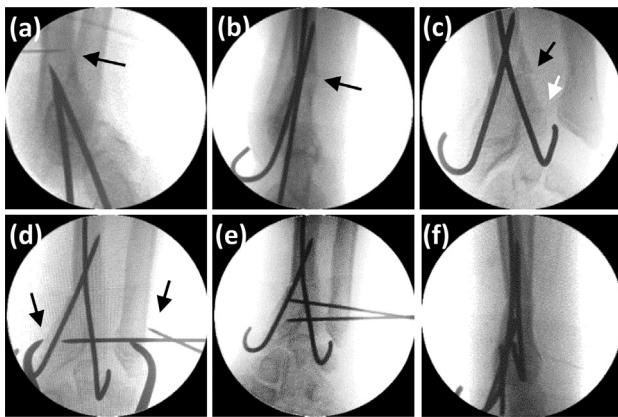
Image intensifier radiographs. (a) Radio-opaque landmark with an 18-gauge needle (black arrow) at Vickers ligament radial origin and two K-wires driven dorsally and aimed at the needle entry point. (b) Volar angulation (black arrow), correcting the volar tilt, after closing the biplane wedge. (c) Ulnar angulation (black arrow), correcting the ulnar tilt, after closing the biplane wedge, distal radioulnar joint leisure (white arrow). (d) Two K-wires were drilled from the distal ulna to the distal radius, while applying compression with a clamp (black arrows). (e) Intraoperative final anteroposterior position; note the minimized distal radioulnar joint gap. (f) Final lateral view after biplane closing wedge osteotomy and distal radioulnar joint K-wire fixation.
